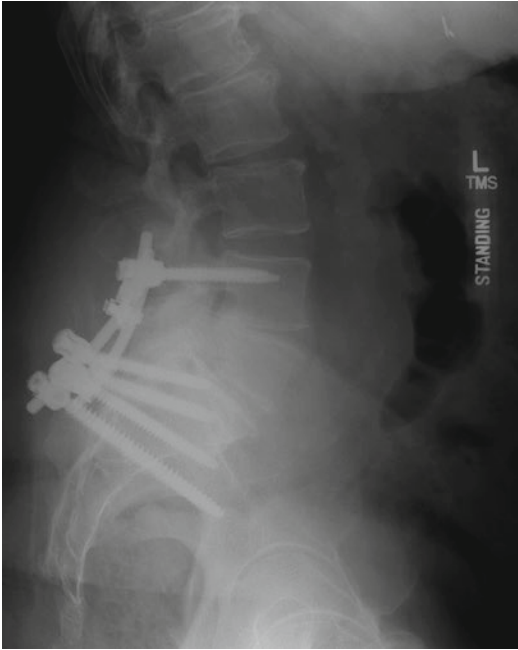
Sagittal standing postoperative radiograph demonstrating L4-iliac fusion with no sign of hardware malposition or failure
